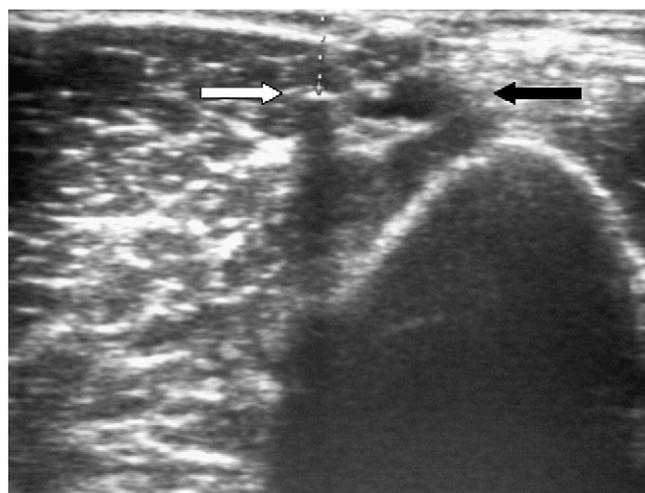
The implant is best visualized by ultrasound on a transverse plane as an echogenic spot (white arrow) with a hypoechoic shadow. The implant is in a deep intramuscular position. Note the close position of the brachial pedicle (black arrow).
